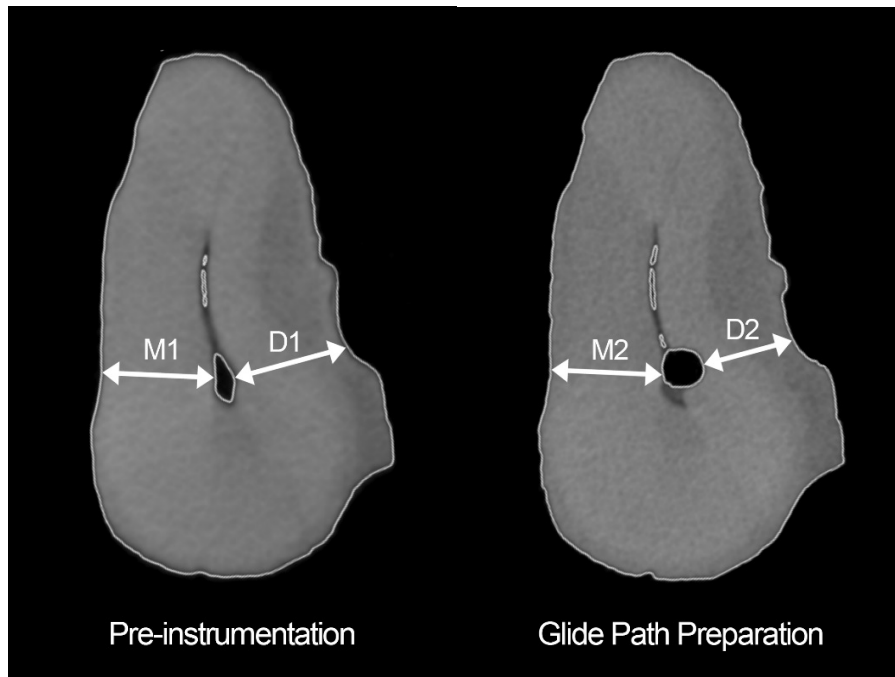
Pre-instrumentation- and post-glide-path-preparation CBCT images showing the effect of glide path preparation and points of measurements used for determination of canal transportation and centering ratio
